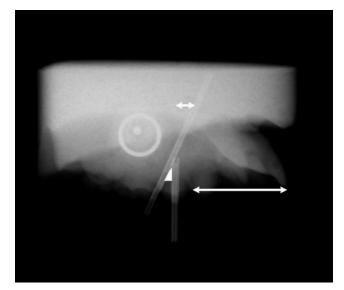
Cephalometric radiograph of the premolar and implant rods inserted in the working model (shown in Figure 3). The implant rod inclination (indicated by the white triangle) is measured relative to the vertical rods. The white arrows indicate the AP linear measurements from the insertion point (through the model surface) to the vertical plane and most prominent incisor
